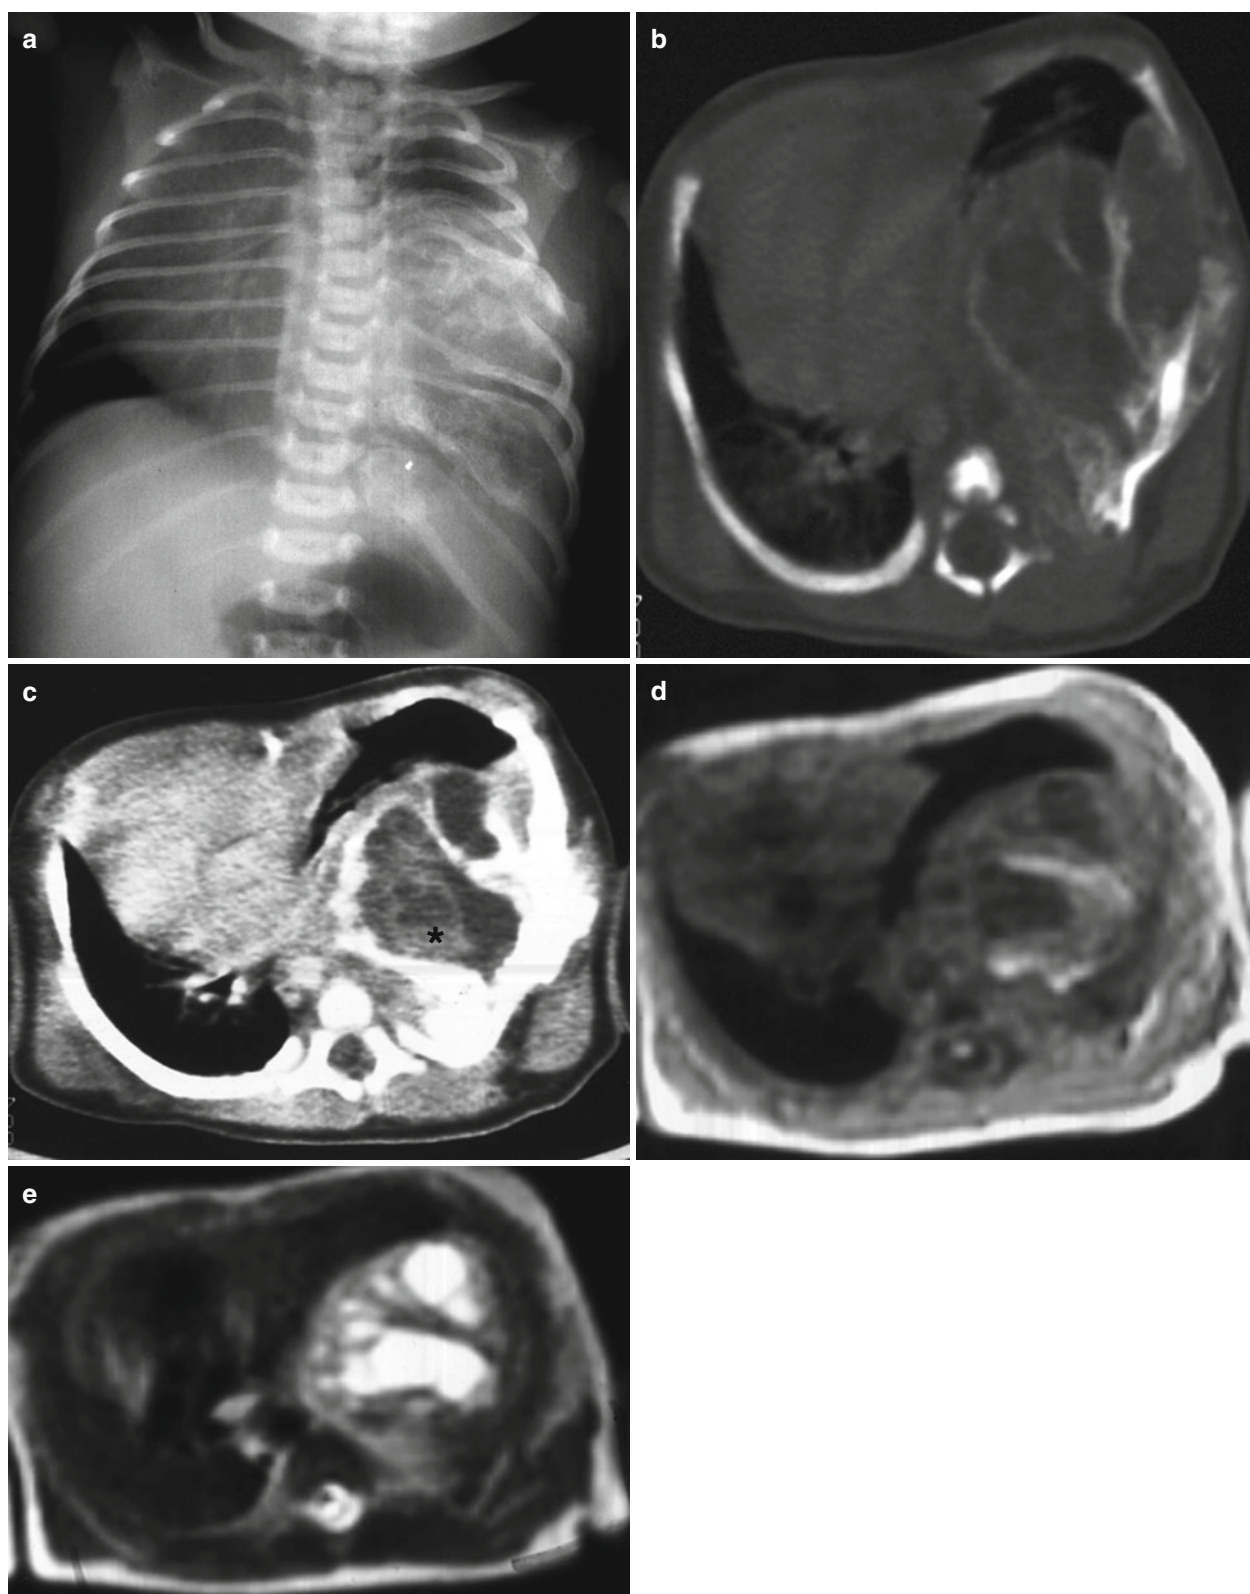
Mesenchymal hamartoma in an infant with an intrathoracic mass found on prenatal US. (a) Plain radiograph shows a large calcified soft tissue mass with multiple rib destruction, thinning, and splaying on the left thorax. (b, c) CT with bone window (b) and contrast-enhanced CT (c) show a large lobulated, extrapleural solid and cystic mass with fluid-fluid levels (*asterisk*). Rib destruction and internal calcification
